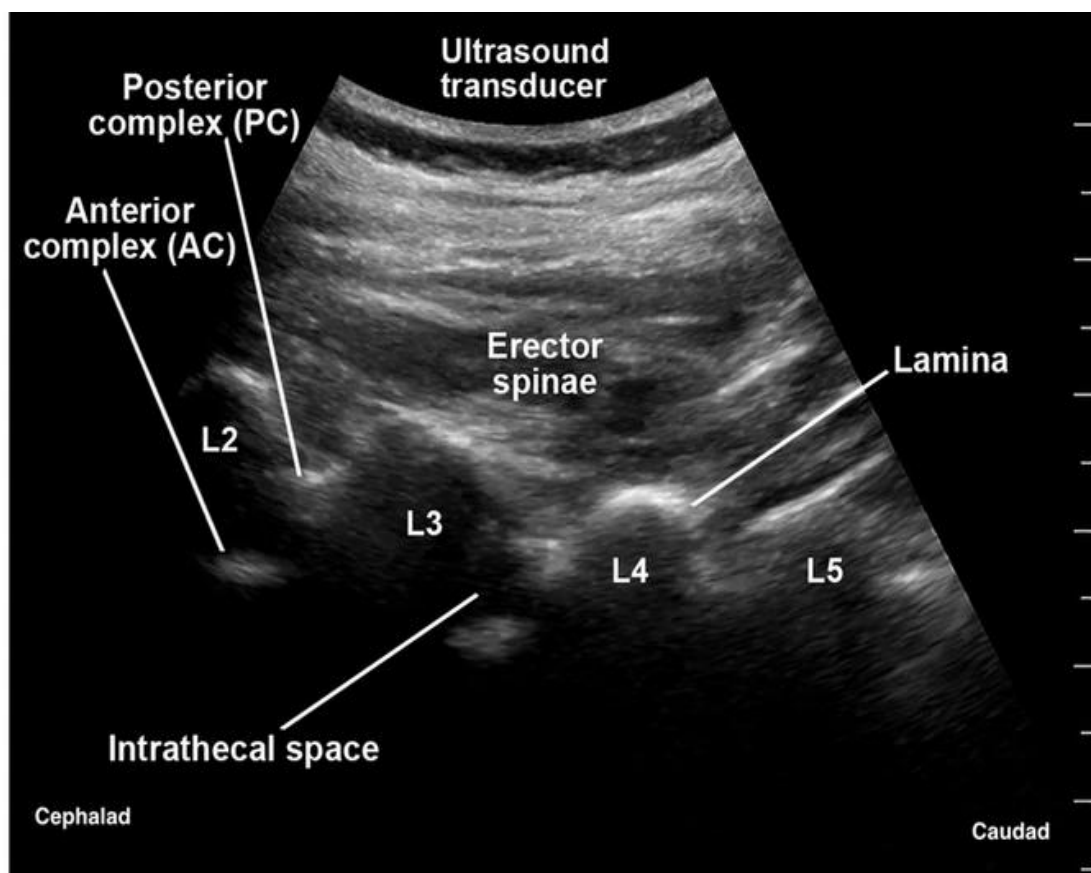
Para sagittal interlaminar ultrasound oblique view.
